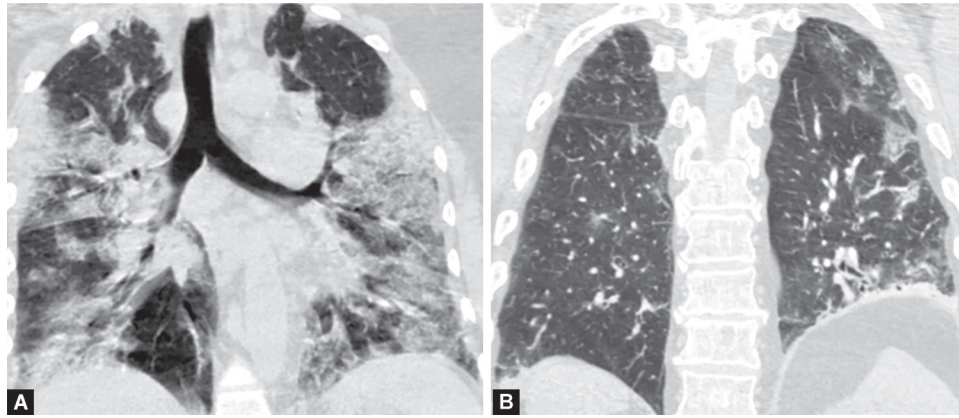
HRCT chest of a 52-year-old male with severe COVID-19 disease. (A) Before TCZ transfusion showed bilateral diffuse ground-glass opacities with a CT severity score of 20/25; (B) After TCZ transfusion with a clinical improvement, suggestive of reduced opacities with a CT severity score of 9/25
